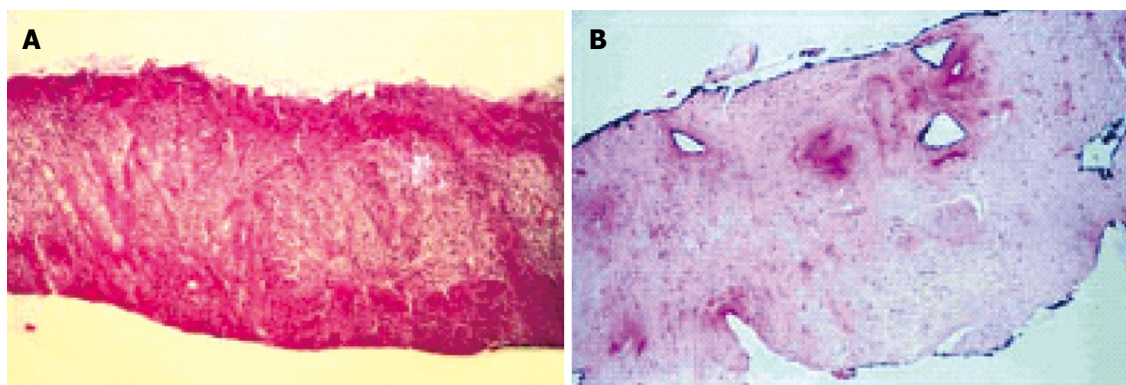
Complete destruction of the glandular tissue due to coagulation necrosis lesion which reaches the capsula and the periprostatic fat 48 h after high intensity focused ultrasound treatment (A) and the necrotic prostatic tissue is replaced by a fibrotic tissue, including the capsula, 3 mo after high intensity focused ultrasound therapy (B).
